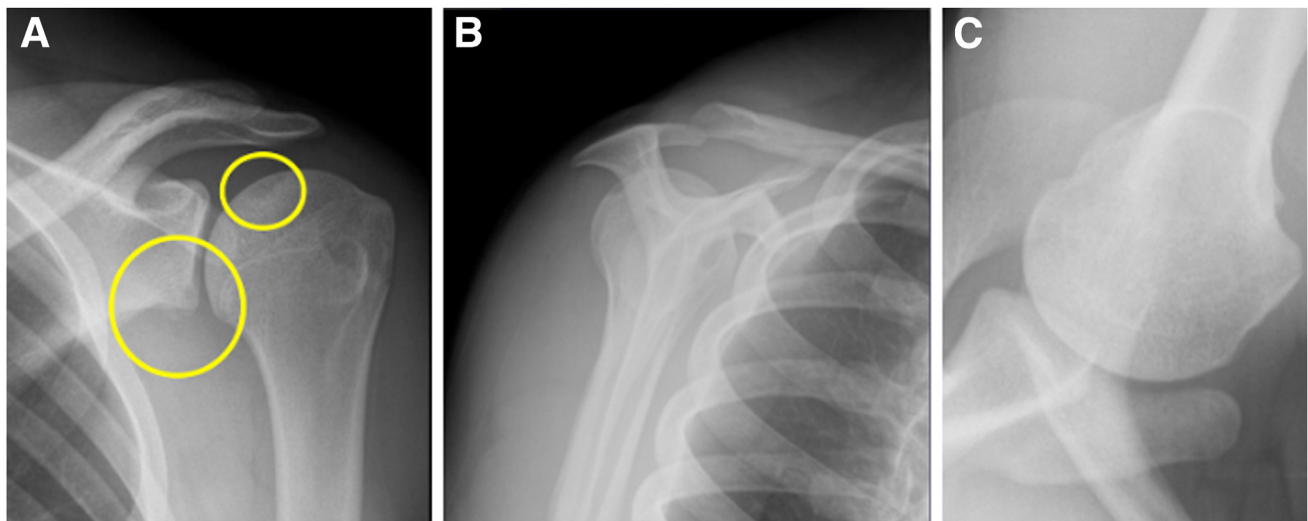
Preoperative radiographs of the left shoulder demonstrating Hill-Sachs lesion of the posterolateral humeral head (small yellow circle) with anteroinferior glenoid bone loss (larger yellow circle). Views include Grashey (A), scapular-Y (B), and axillary (C).
